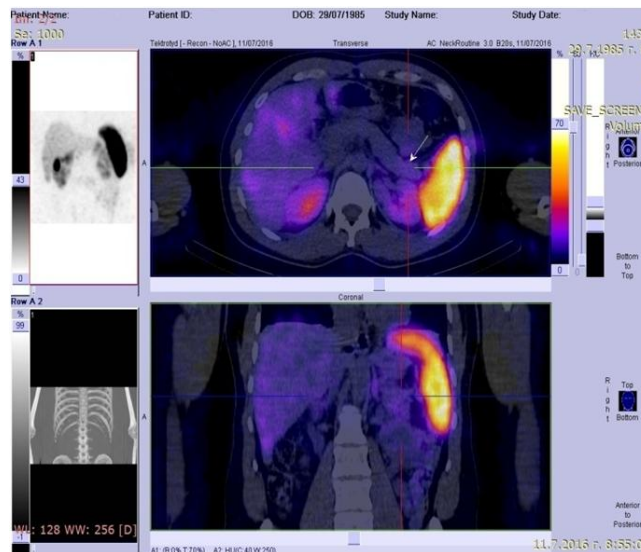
Somatostatin-receptor scintigraphy + SPECT-CT of abdominal organs
